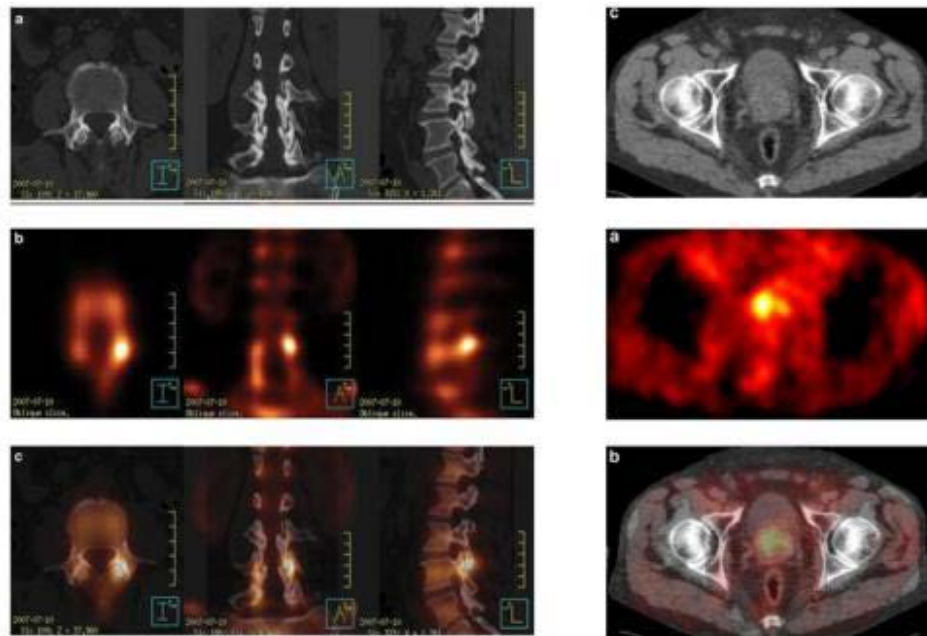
MRI / PET multimodal fusion examples:
